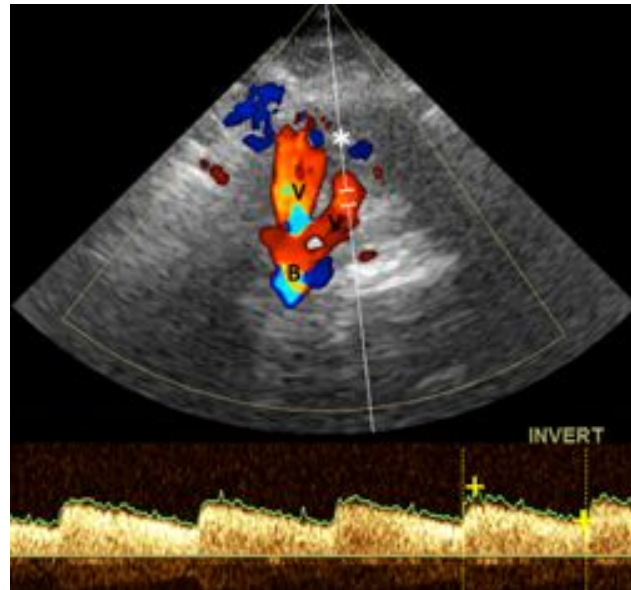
Color Doppler image of the paired vertebral (V) and basilar (B) arteries with a spectral tracing obtained from the right vertebral artery. * indicates medulla.
